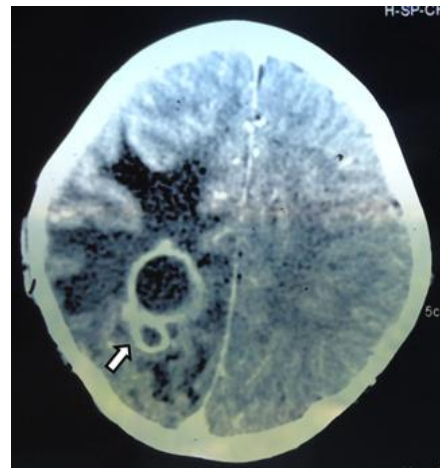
CT image of cerebral abscess with sacculations(↔)
